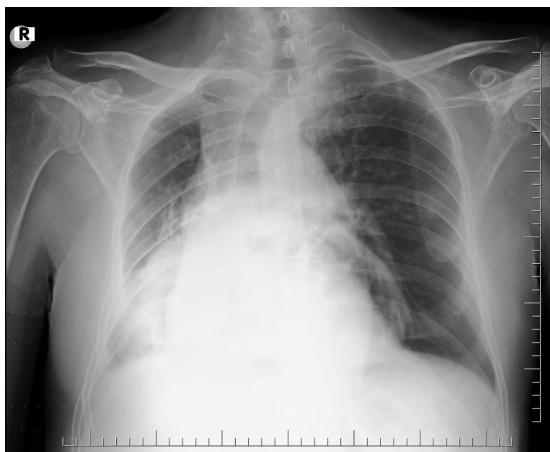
Chest radiograph demonstrating consolidation in right lower lobe associated with volume loss in ipsilateral hemithorax.
